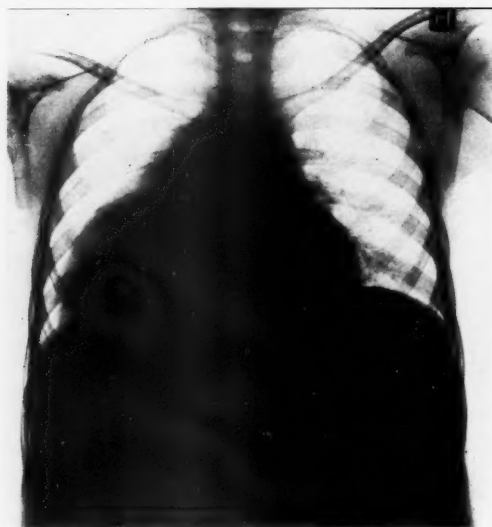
X-ray of the chest 2 months before death. Note the absence of pulmonary fibrosis. H = right side.
